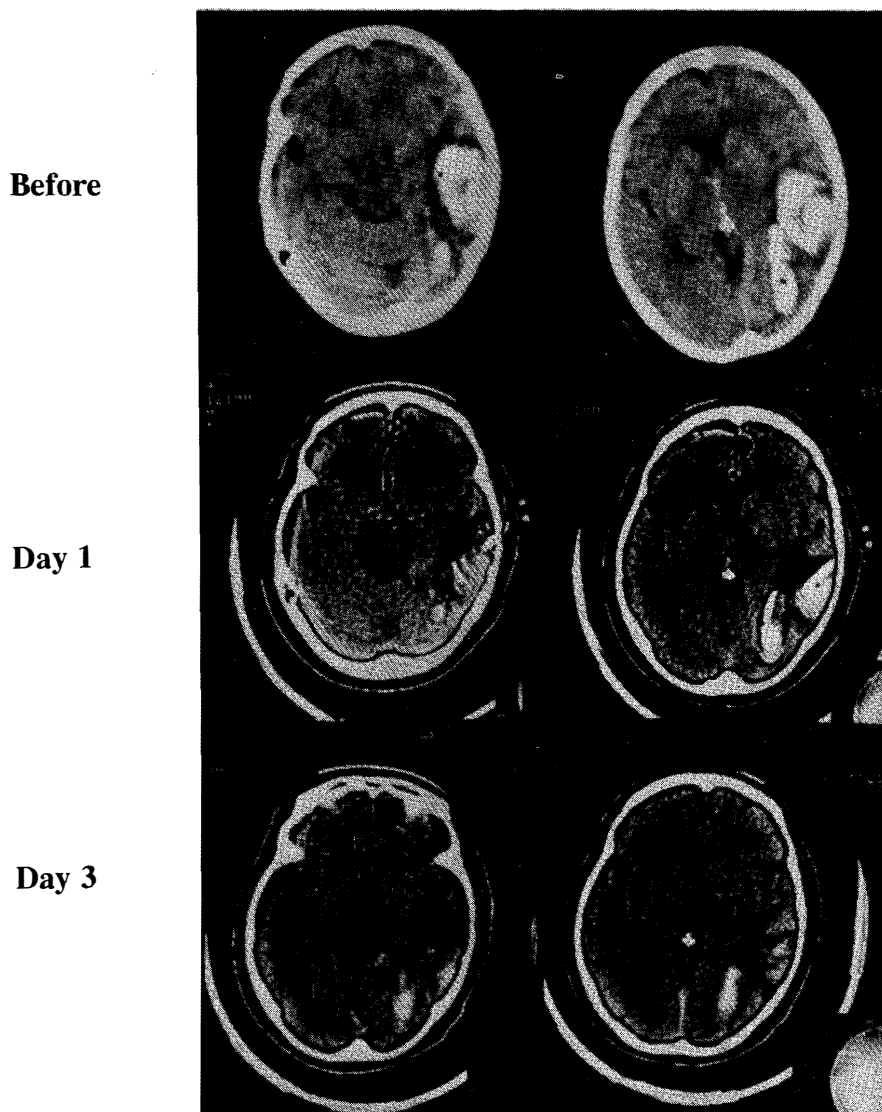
CT findings in case 15 before and after urokinase infusion therapy.
